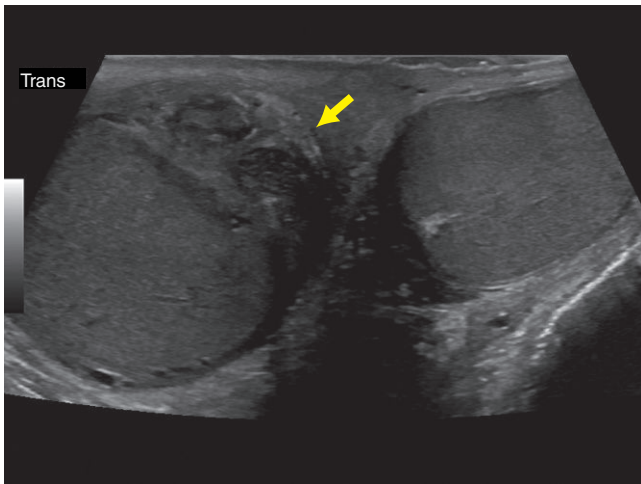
Transverse ultrasound in another patient showing enlarged epididymis (arrow).
